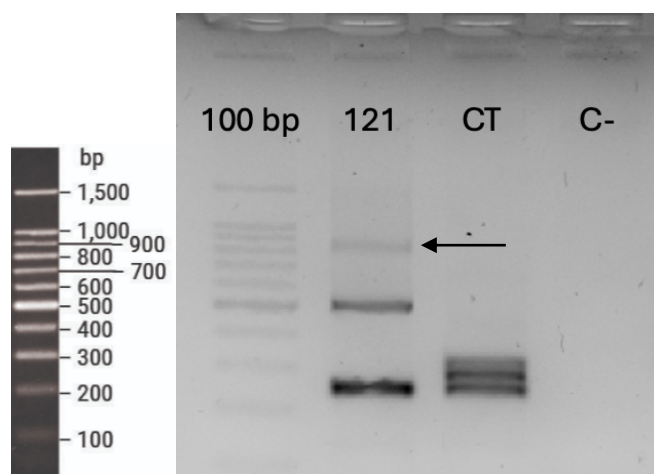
Conventional flanking PCR analysis of *CMKLR2-AS*: Agarose gel electrophoresis of PCR products obtained from patient #121, a control sample and a negative control. Patient #121 showed two amplification products of approximately 250 bp and 500 bp. The additional upper band, indicated by the arrow, was interpreted as a non-specific product; CT, control sample; C-, negative control; 100bp, 100 bp DNA ladder (Promega).
